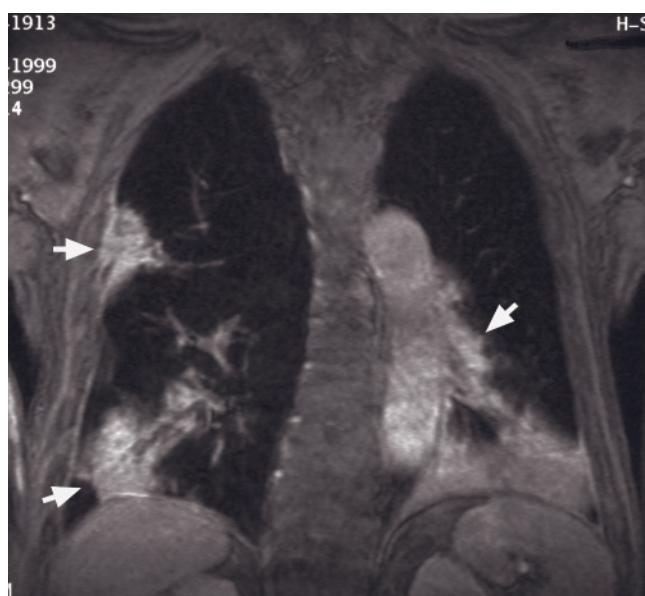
Pulmonary infiltrate. T2-weighted ETSE (a, c, o, s), T2-weighted fat-suppressed ETSE (e, f, m, p, t), and post-gadolinium fat-suppressed 3D-GRE images (b, d, g, h, j, k, l, n, q, r, u) in nine patients with pulmonary infiltrates (arrows):
